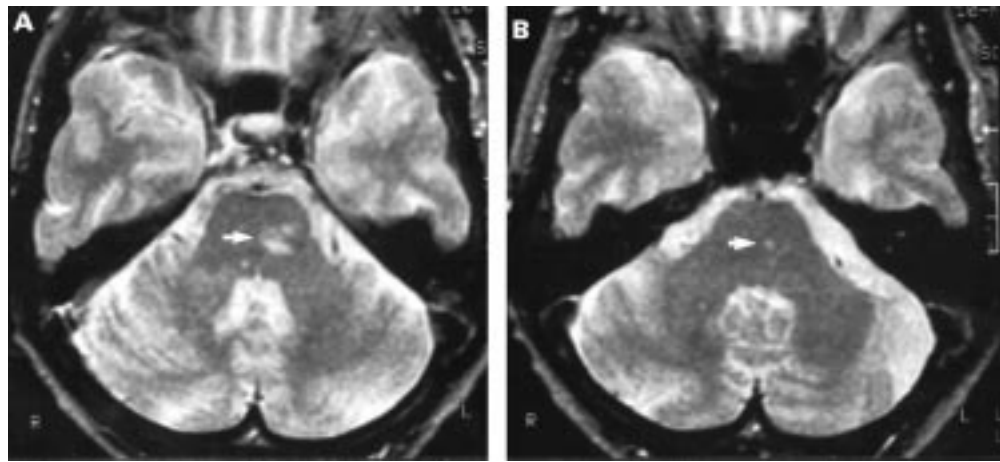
T2 Weighted MRI in an 80 year old woman (patient 45) with left sided vestibular paresis documenting an ipsilateral pontine lesion compatible with infarction. The lesion was mainly above the level of the vestibular nerve entry zone (left side) and extended to the level of the labyrinth (right side). Although main portions of the lesion were outside the region of the intrapontine vestibular nerve, it may have affected portions of the nerve causing mild canal paresis.
